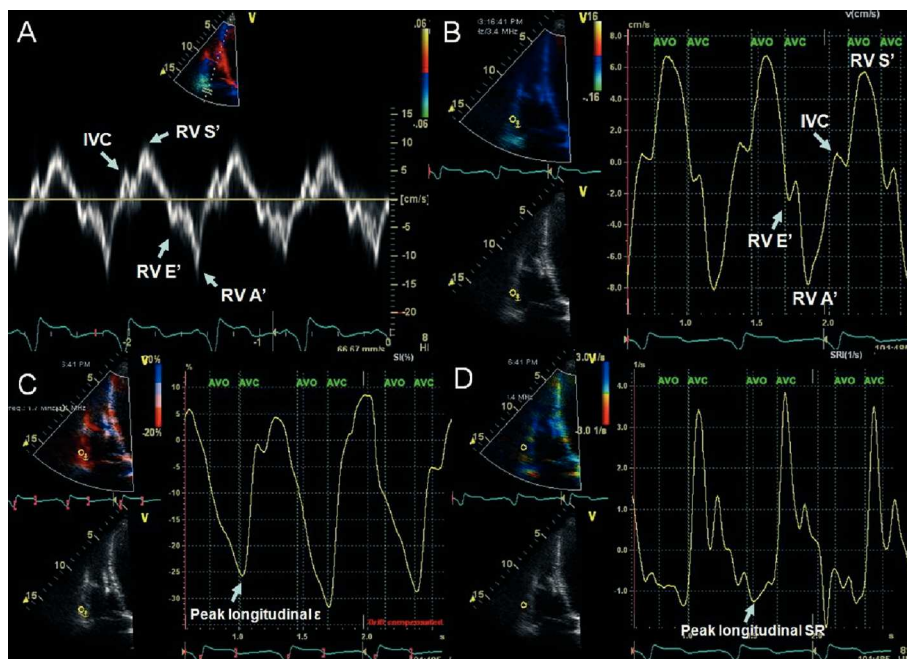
Example of tissue Doppler imaging (TDI) and strain imaging displayed in a subject with normal right ventricular (RV) function. A: spectral TDI waveforms of systolic and diastolic RV function from the lateral tricuspid annulus. B: color TDI phases with the sample volume placed at the basal RV wall. C: strain imaging with peak longitudinal systolic strain of -26% , and D: strain rate of -1.4 s^{-1} , both at the RV basal level. AVO indicates aortic valve opening; AVC, aortic valve closure; IVC, isovolumetric contraction peak positive velocity; RV A', atrial peak velocity (right atrial contraction); RV E', early diastolic peak velocity (during peak RV relaxation); RV S', systolic (ejection) peak velocity (during mechanical systole).
